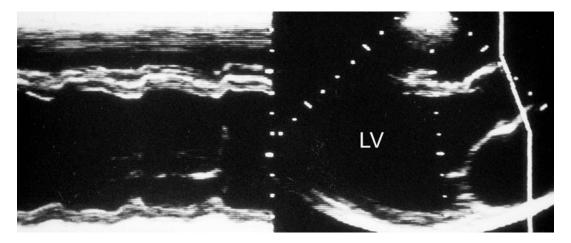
M-mode echocardiogram (left) and parasternal long-axis view from a patient with marked alcohol consumption and heart failure. The echocardiographic pattern is that of dilated cardiomyopathy with reduced contraction
